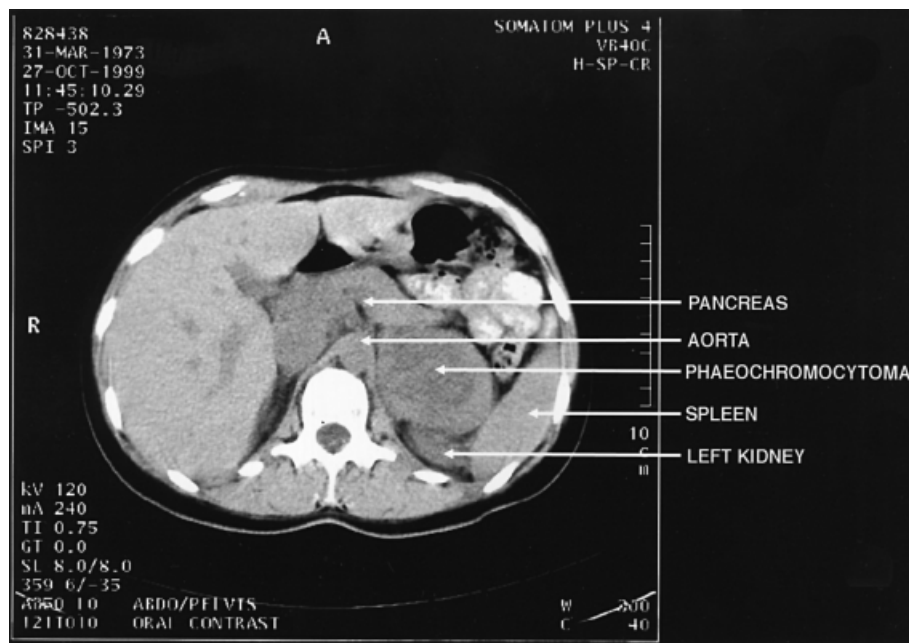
MRI scan of a patient with a moderately large left-sided phaeochromocytoma.
